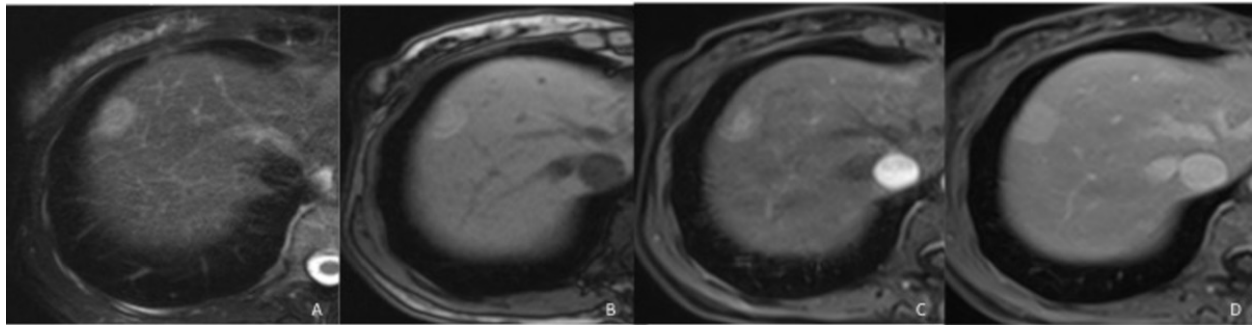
Inflammatory hepatocellular adenoma. Focal hepatic lesion that are hyperintense on the T2 (A) and T1-weighted images (B). Contrast-enhanced T1-weighted MR images obtained in the arterial (C) and portal venous (D) phases show the lesion with arterial phase enhancement, which persists into the portal venous phase.
